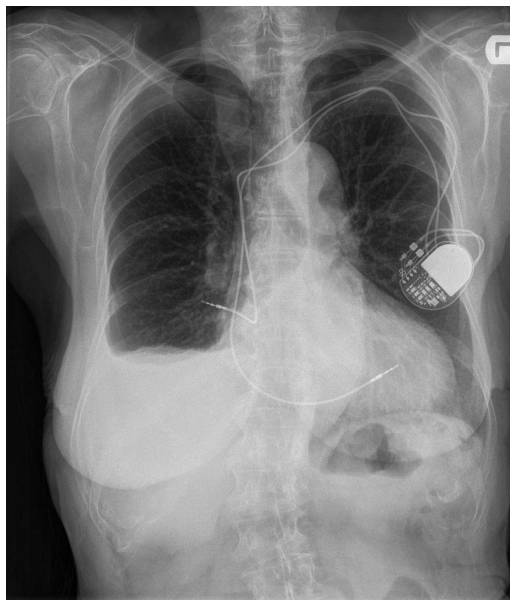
Chest radiograph 6 weeks after device implantation showing the atrial lead has perforated the atrial wall.
